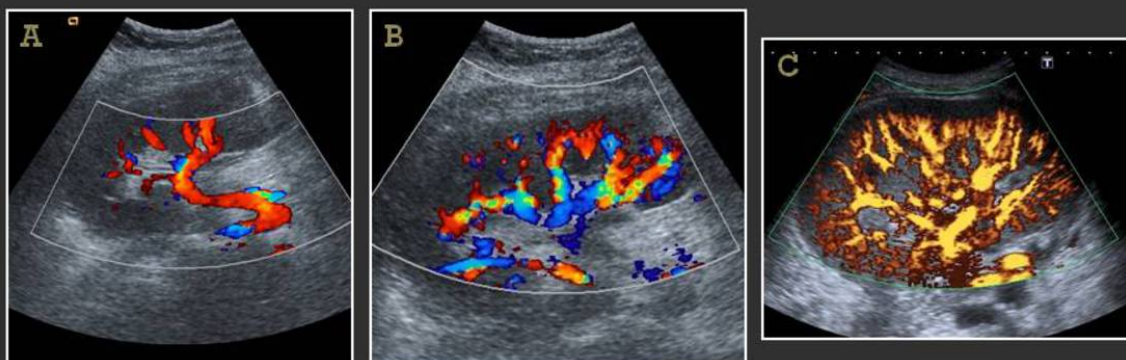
Vascular supply and drainage are best seen using color Doppler. The poles may not show as many small vessels as the midportion, because the blood flows at right angles to the Doppler beam. By tilting (heeling and toeing) the transducer, this problem can be mitigated but not always eliminated, hence in practice, slight doubt may remain about polar flow. (A and B).
